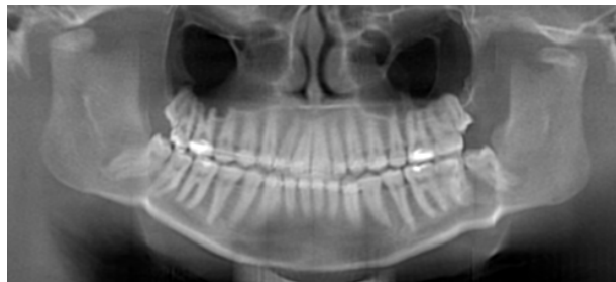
Reconstructed panoramic view taken by CBCT shows condylar fracture in the both side.
